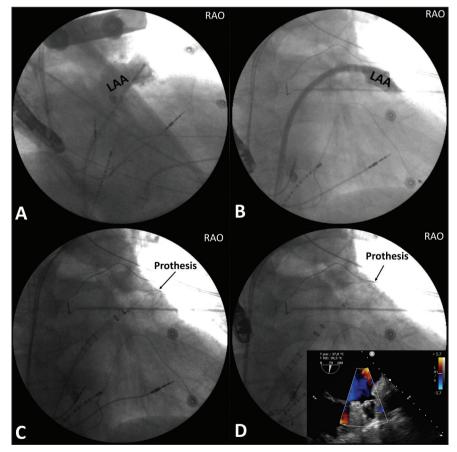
Left atrial appendage occlusion using a Watchman device. Left atrium appendage (A) morphology and position was identified using contrast injection using a pigtail catheter, (B) then the sheath with radiopaque markers was advanced on the appendage, (C) then the prothesis is advanced and checked the position on transesophageal echocardiogram (TEE) and using contrast injection, (D) and finally the prothesis is deployed and final position is checked on fluoroscopy and TEE.
